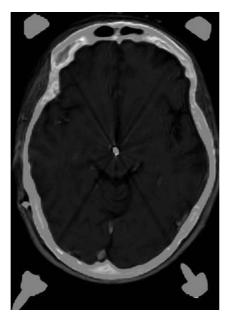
Post-operative neuroimage with computerized tomographic and magnetic resonance images showing the localization of deep brain electrode's tip at the inferior portion of the posterior hypothalamic area.
